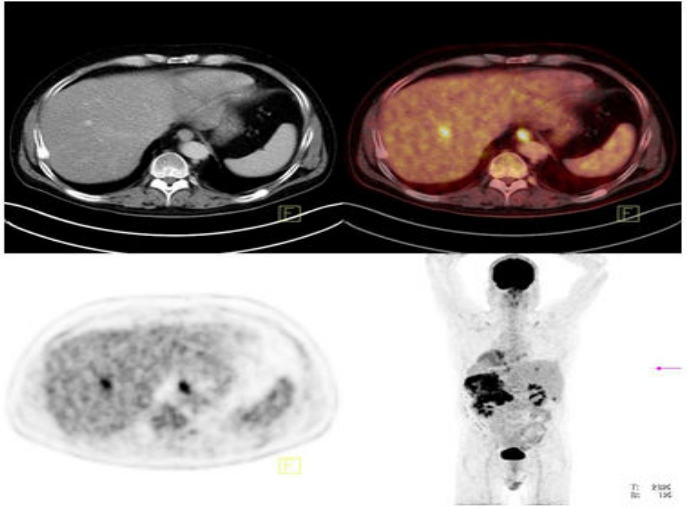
Demonstrate the CT results in comparison to the 18F-FDG PET/CT results.
